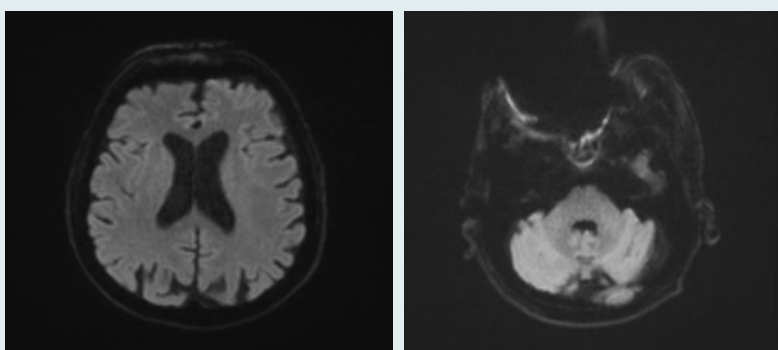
Brain MRI (DWI): no acute ischemic lesions.
